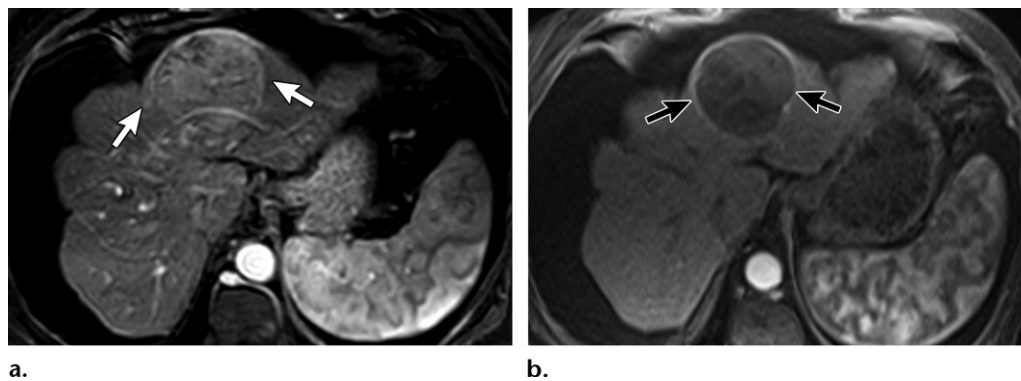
Ring enhancement in a 73-year-old woman with HCC. (a) Axial pretreatment arterial phase MR image shows HCC (arrows) in the left liver lobe. (b) Axial post-TARE arterial phase follow-up MR image shows that the lesion is stable in size but with complete necrosis and ring enhancement (arrows), indicating a complete radiologic response.
